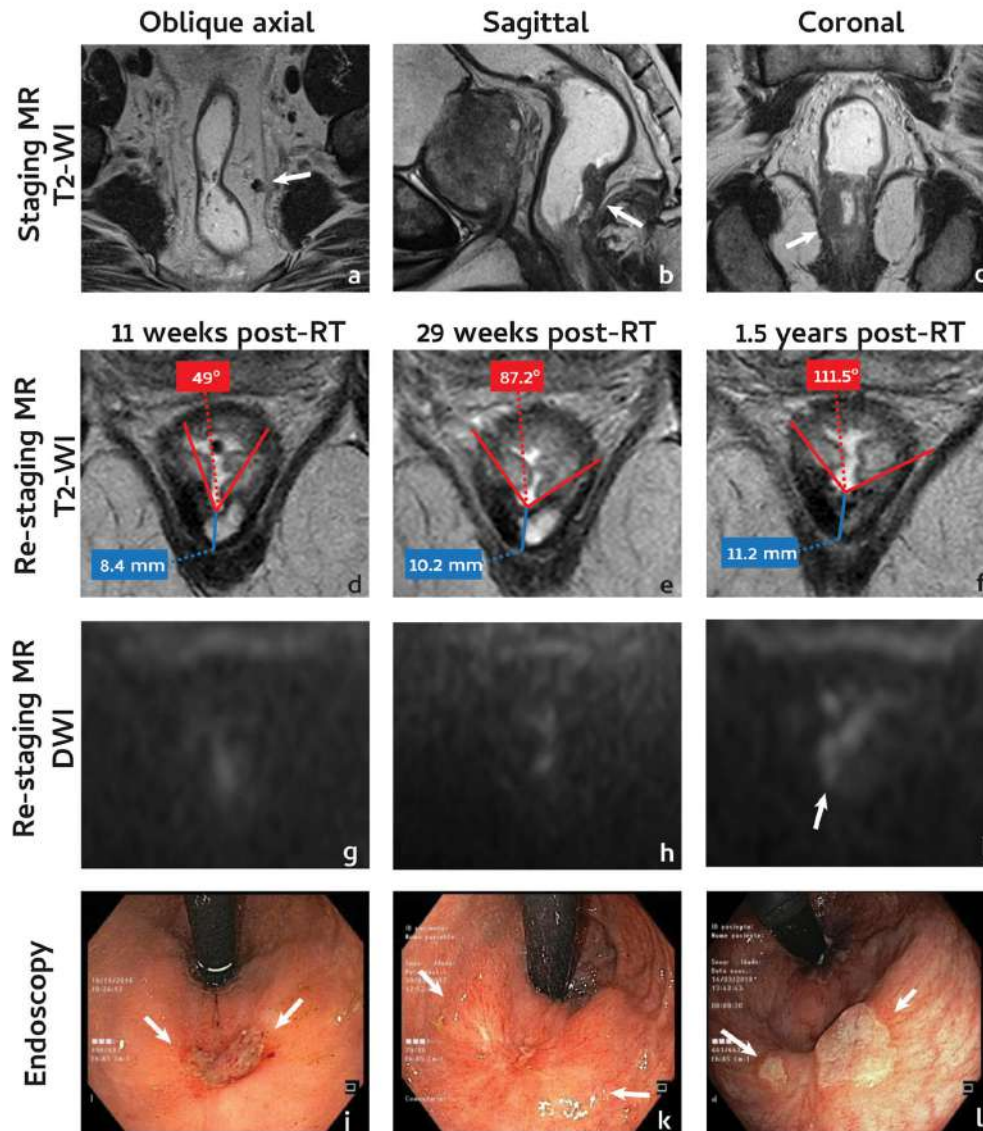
Sixty-seven years old male with a mucinous low rectal cancer, mrT3 mrN1 EMVI- MRF + . Tumour was located posteriorly (arrow in b) and abutted the right levator ani (arrow in c). A positive lymph node is depicted in a (arrow). Patient underwent CRT. At first assessment, response was graded mrTRG2 (d), was negative on DWI(g) and grade 1 on endoscopy (shallow ulcer between arrows in j). At second assessment, mrTRG and DWI remained stable (e,h) as well as endoscopic grade (red scar between arrows in k). However, the scar lost its concavity (+ 38.2°) and increased in thickness, being higher than 10 mm (e). Patient was followed and at 1.5 years, intermediate tumour signal became apparent within the scar (f), DWI became faintly positive at the same location (arrow in i) while scar thickness and angle further increased (f). Patient underwent an APE and was staged as ypT2N0R0.
